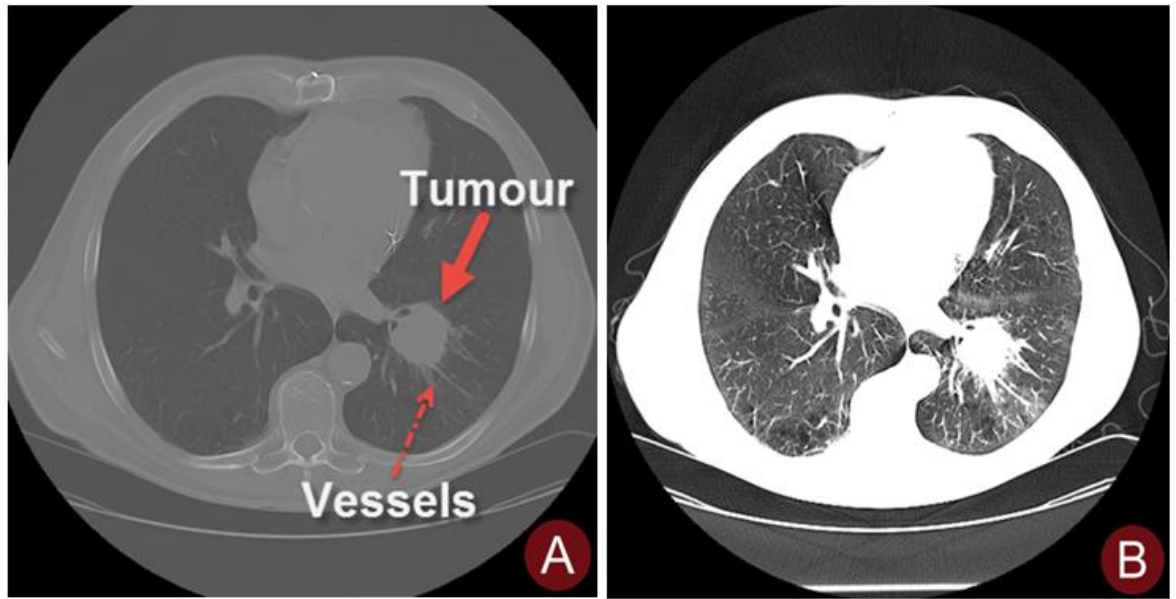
(A) Shows 2D contrast-enhanced CT images showing vessel-like structures in the lung (the image is from the original dataset). (B) Shows an enhanced view of vessel-like structures following specific windowing.
